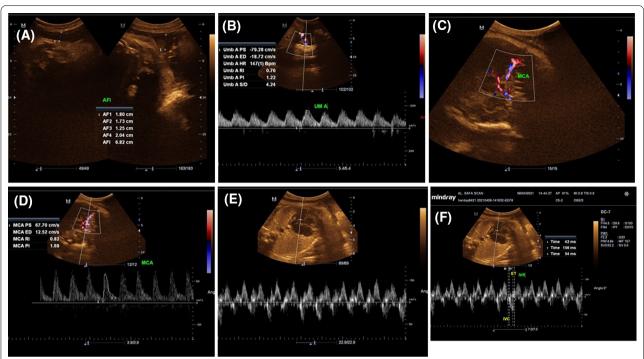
A 33-year-old patient was examined at 32 weeks gestation, had an US foetal age of 28 weeks and foetal weight of 1050 gm. A Ultrasound showing oligohydramnios with decreased amniotic fluid index. B Doppler US of umbilical artery showing increased pulsatility index with preserved antegrade diastolic waveform pattern. C and D Colour Doppler assessment of middle cerebral artery (MCA) in a growth-restricted foetus. A, at level of circle of Willis.B, flow velocity waveform with normal pulsatility index of MCA. E Apical 4-chamber view of the foetal heart showing location of the sample volume on the internal wall of the ascending aorta, close to the internal leaflet of the mitral valve and below the aortic valve for measurement of the left Mod-MPI. Myocardial performance index (MPI) measured in the left ventricle. The Doppler waveform displays the clicks of aperture and closure of the mitral and aortic valves. F showing reference points for time periods estimations for measurement of IVCT, ET and IVRT based on echoes from the opening and closure of the mitral and aortic valves with a calculated MPI = 0.61
